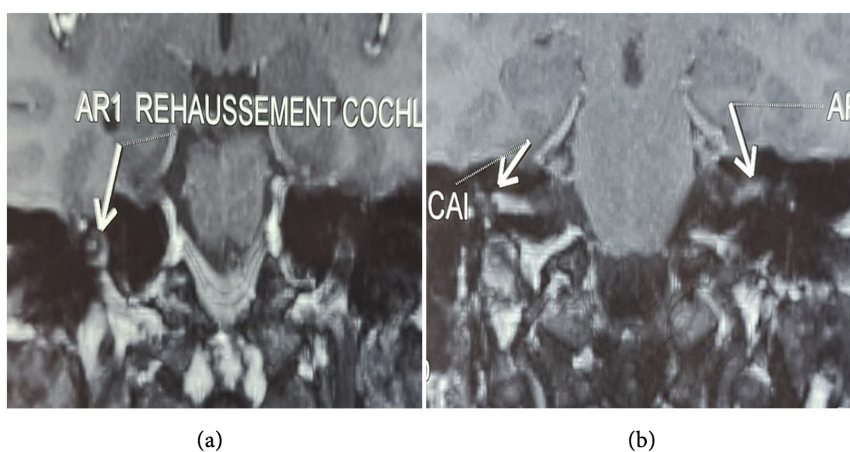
Coronal view MRI of the temporal bone showing enhancement of the right cochlea (a) and internal auditory canal (IAC) (b).
